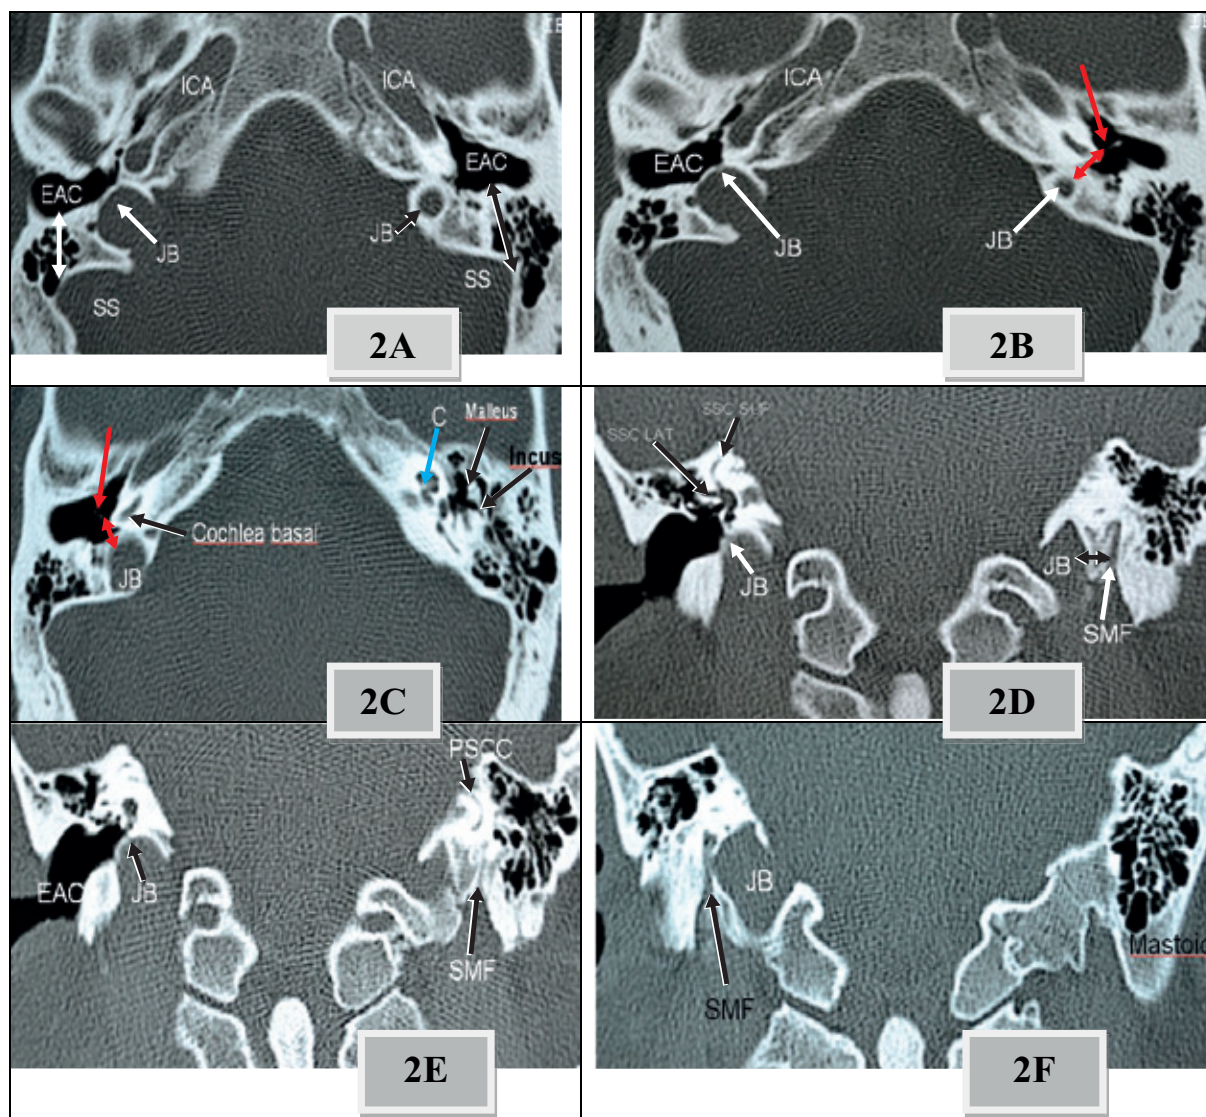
Bilateral high jugular bulb was demonstrated in the temporal bone HRCTs. 2A. Bilateral SS-EAC distance was shown in the axial section of the temporal bone HRCT (a double-tipped white arrow in the right side, a double-tipped black arrow in the left side). 2B. Right JB dehiscence (white arrow), left JB-ED length (a double-tipped red arrow), and manubrium mallei and umbo (red arrow) were shown in the axial section of the temporal bone HRCTs. 2C. Right JB-ED distance (a double-tipped red arrow), manubrium mallei and umbo (red arrow), and cochlea (C) (blue arrow) were shown in the axial section of the temporal bone HRCTs. 2D. Right JB dehiscence (white arrow), SMF-JB distance (a double-tipped black arrow), and SSC SUP and SSC LAT were shown in the coronal section of the temporal bone HRCTs. 2E. Right JB dehiscence (black arrow) and left SMF and PSSC (black arrows) were shown on the coronal section of the temporal bone HRCTs. 2F. Right SMF-JB distance (a double-tipped black arrow) was shown on the coronal section of the temporal bone HRCTs. SMF – stylomastoid foramen, JB – jugular bulb, EAC – external acoustic canal, SS – sigmoid sinus, PSSC – posterior semicircular canal, SSC SUP – superior semicircular canal, SSC LAT – lateral semicircular canal
